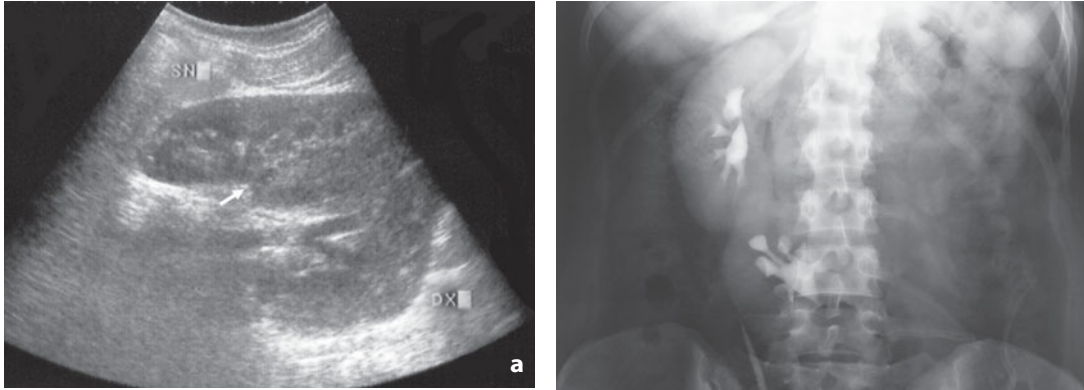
Crossed renal ectopia. a Transverse sonogram shows right crossed renal ectopia with the right kidney located in the left hemiabdomen and the upper pole fused to the lower pole of the left kidney (*arrow*). b Intravenous urography in the excretory phase confirms right crossed renal ectopia with the ureter inserting in the opposite hemiabdomen
